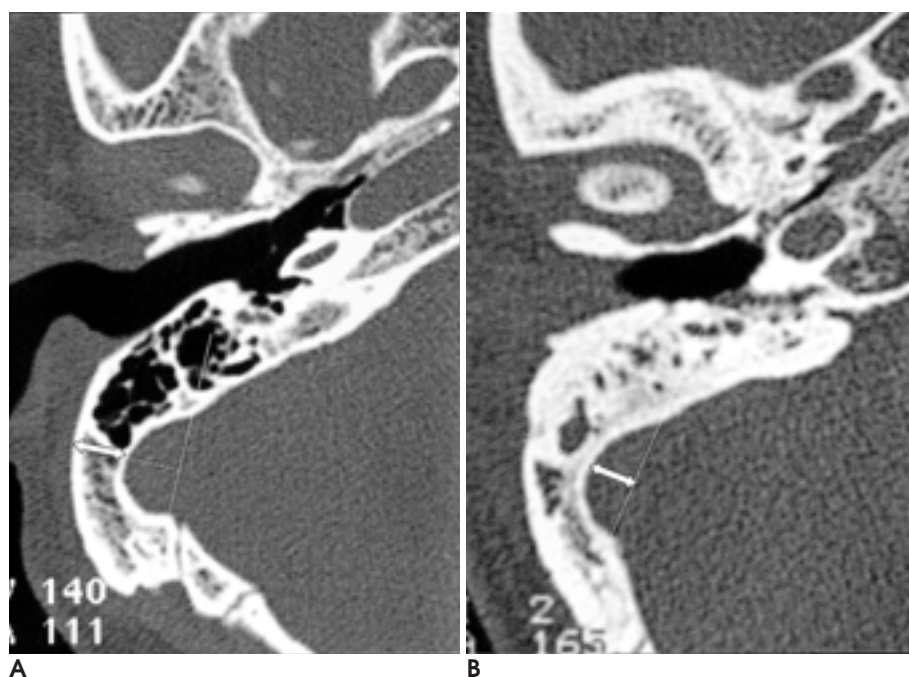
Axial computed tomography of temporal bone at the level of external auditory canal
